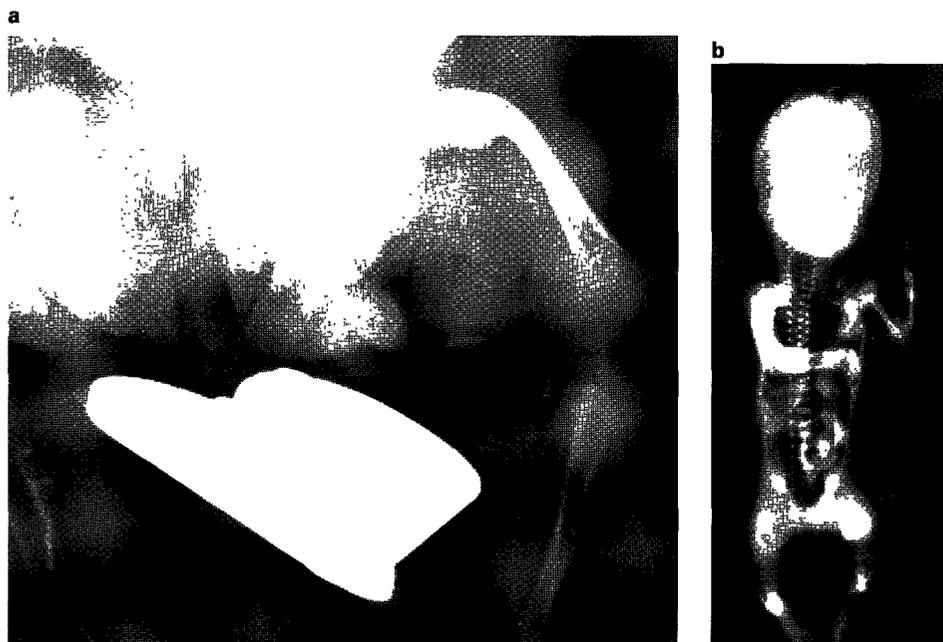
a X-ray of the proband's lower limbs at 1 year. b X-ray of the second fetus aborted after 22 weeks of gestation.
